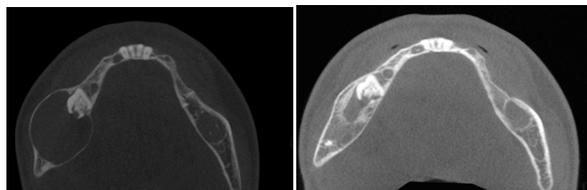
Preoperative and follow up Axial CBCT cuts showing lesion is reduced in size and new bone formation
